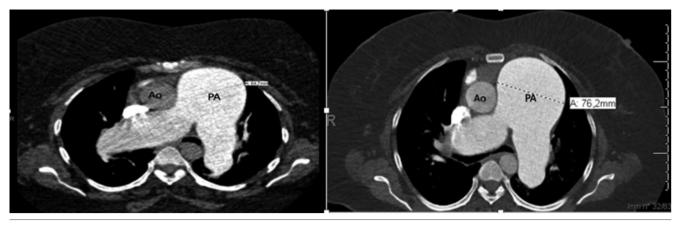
Pulmonary artery at 2019 CT. The CT evidenced a PA dimension of 64.7 mm (left) and a rapid PA enlargement of 76.2 mm (right). PA, pulmonary artery; Ao, aorta.
